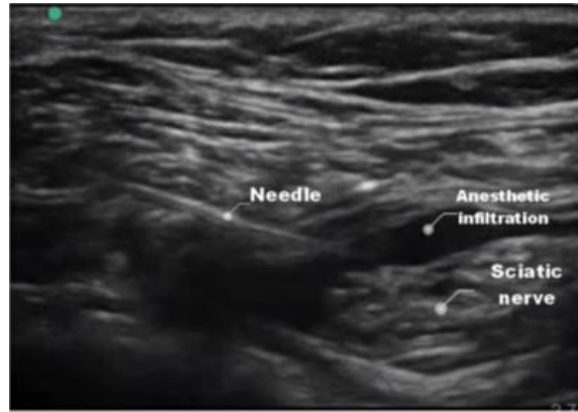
Visualization of the sciatic nerve on ultrasound.⁷
